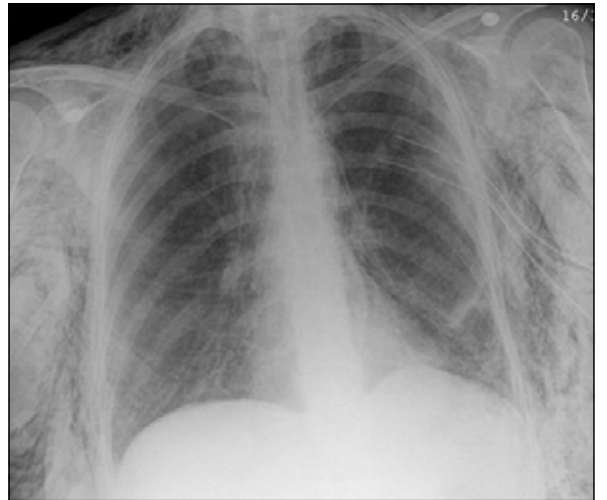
Chest X-ray showing an incorrectly placed right basal intercostal chest drain, which is neither draining pleural fluid or a pneumothorax.
